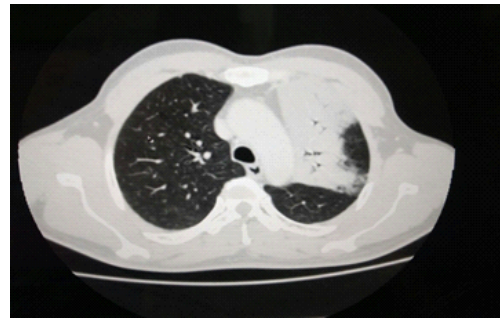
CT scan thorax showing left upper lobe consolidation
